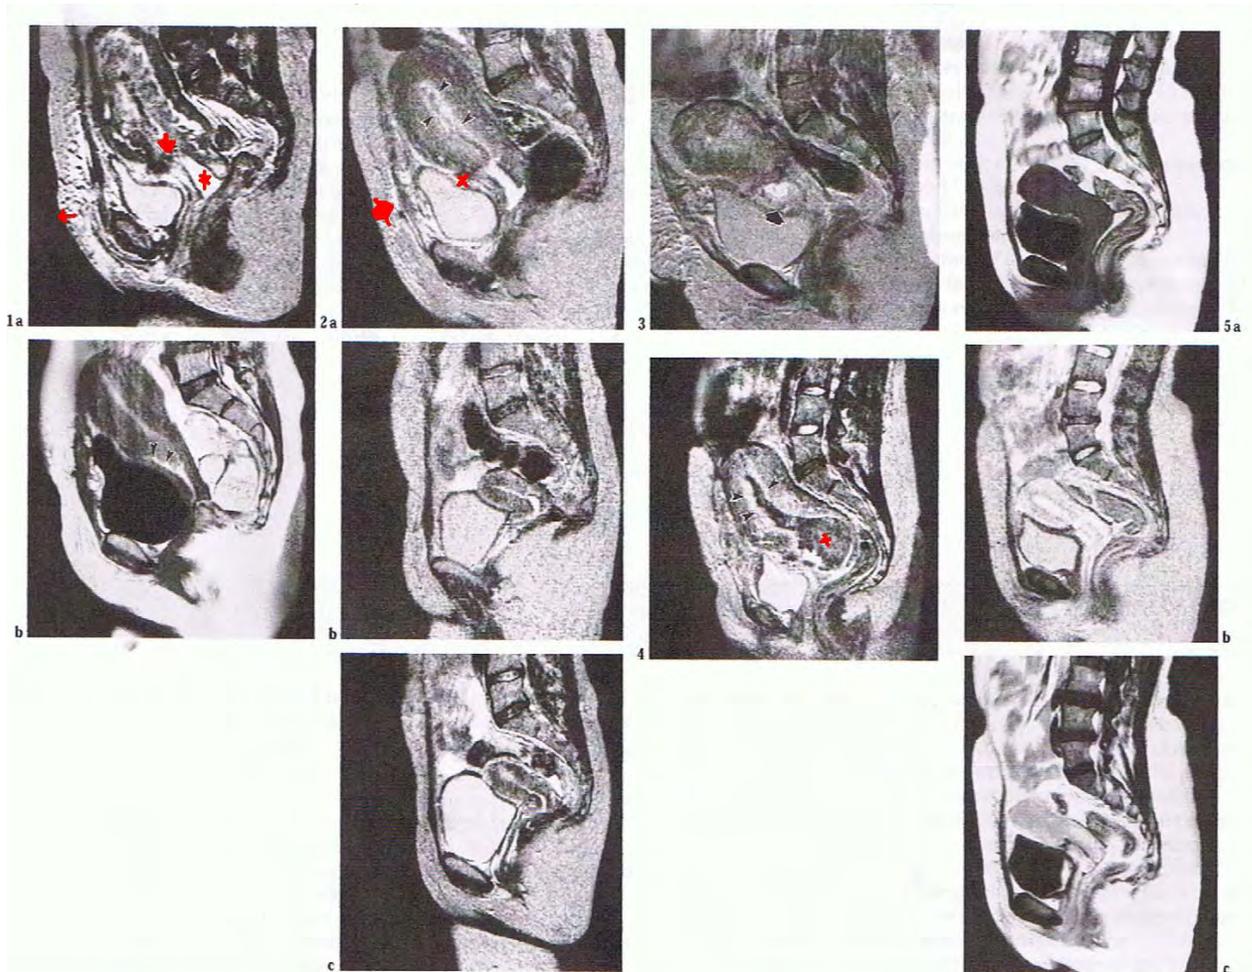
MRI of incision healing after Caesarean Section (Dicle et al, 1996)
